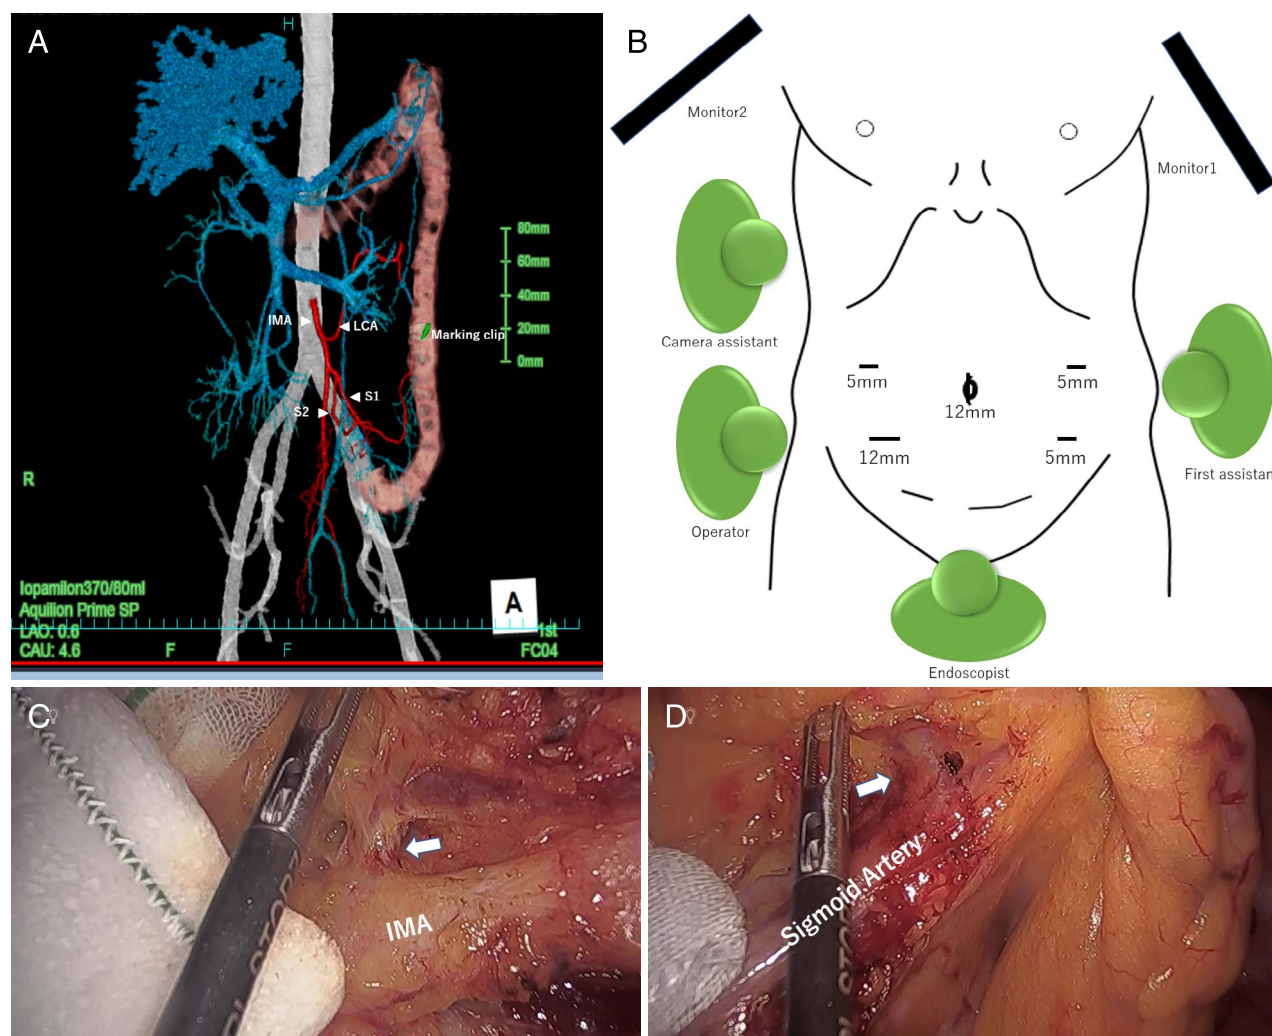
Preoperative CT and intraoperative finding, and operating room setting. Legends: (A) Preoperative 3D CT Imaging. This is useful for the confirmation of IMA branching form and arcade formation. (B) With the patient in the open-leg position, the surgery is performed with 5 ports. Endoscopist is positioned between the legs, the endoscope is performed. (C) LCA branching from the IMA can be confirmed by preoperative imaging (arrow). (D) Sub-branching of the sigmoid arteries can be confirmed by preoperative imaging (arrow).
